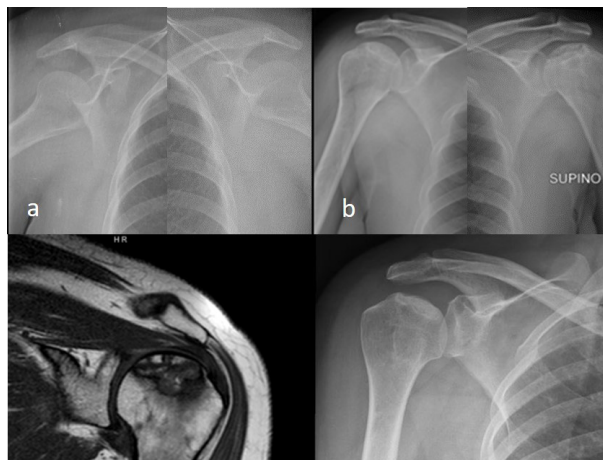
2015 normal radiographs (a) and 3 years later, (b) crescent sign in both the humeral heads; (c) MR T1_TSE of right humerus with precollapsed stage of AVN (2018) and (d) left humeral head collapse (2020).
